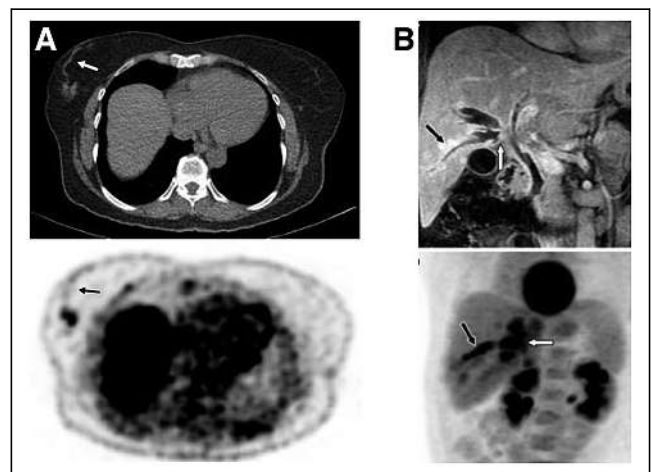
(A) Transaxial CT and ^{18}F -FDG PET images of patient with tubular breast cancer show hypermetabolic primary tumor as well as linear mild activity representing intraluminal tumor uptake either in mammary duct extending to nipple or in lymphatic channel extending to Sappey plexus (arrows). (B) Infiltrating perihilar cholangiocarcinoma with peribiliary extension. Coronal T1-weighted contrast-enhanced MR image (top) shows enhancing tumor of confluence of right ducts (white arrow), intrahepatic ductal dilation, and enhancing right peribiliary extension (black arrow), and ^{18}F -FDG PET maximum-intensity-projection image (bottom) shows ^{18}F -FDG-avid perihilar tumor (white arrow) with peribiliary extension (black arrow). (Adapted from (56).)
